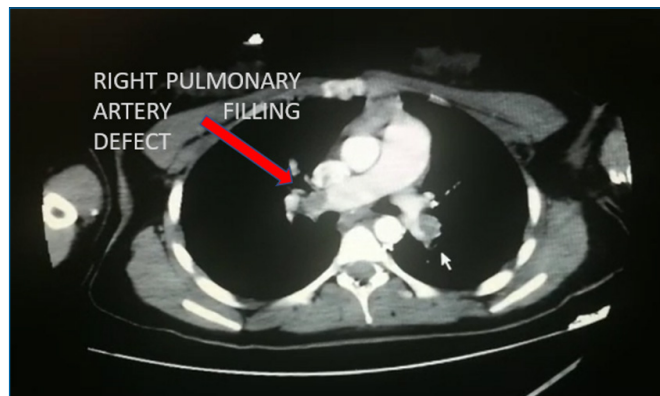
Right pulmonary artery filling defect in computed tomography pulmoner angiogram.
